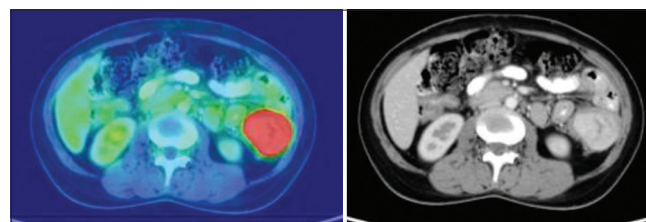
A large well-defined intensely enhancing lesion in the left lumbar region indenting the proximal descending colon with no luminal compromise - probably retroperitoneal in location (Metabolically active, SUVmax 21.62). Biopsy of the lesion was consistent with myofibroblastic tumor. (True positive positron emission tomography-computed tomography scan)
